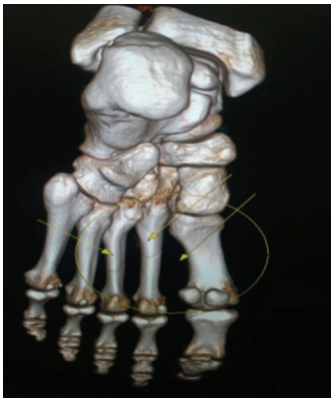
Computed tomography on December 12, 2016 revealed cortical fracture at the base of the first metatarsal bone.
